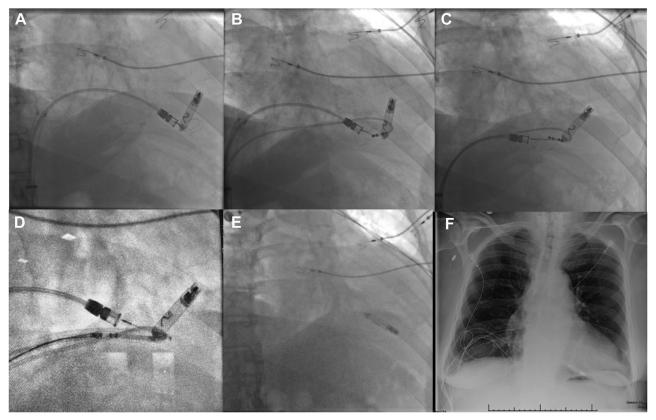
A: Initial fluoroscopic image of the device with an attempt to remove this with the Abbott Medical trileaflet snare and docking system (Supplemental Video 1). B and C: Navigation of a quadripolar catheter to free the septal aspect of the device and attempts to free the proximal end with additional traction and support from the trileaflet snare (Supplemental Videos 2 and 3). D: Magnified image of the quadripolar catheter held on the distal end by a gooseneck snare to lift the proximal end and hold it in place before snaring of the docking button. E and F: Final fluoroscopic and next-day radiographic imaging of the newly inserted pacemaker.
